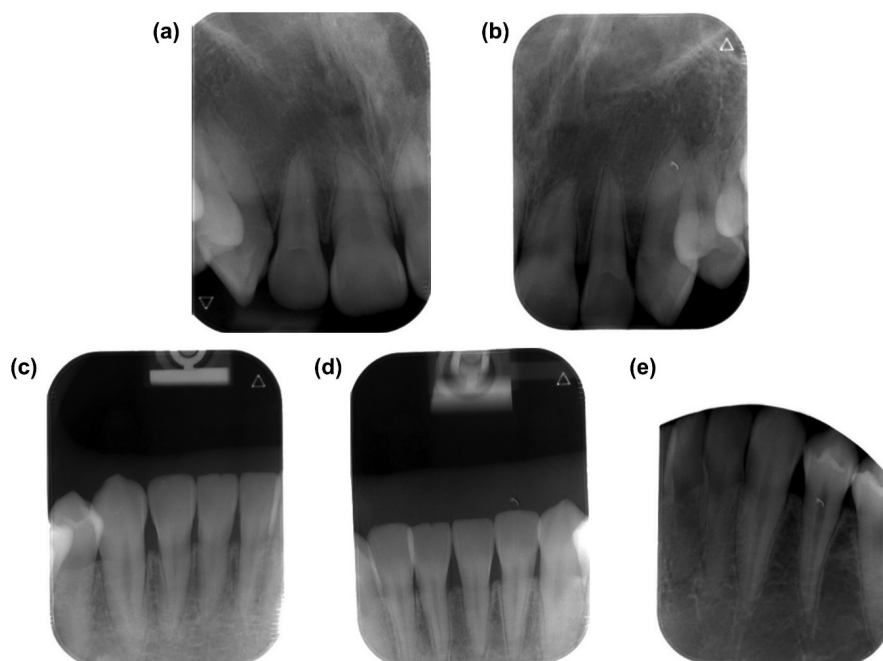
Radiographic images at initial presentation. Intraoral radiographs were taken at (a) right maxillary anterior teeth region, (b) left maxillary anterior teeth region, (c) right mandibular anterior teeth region, (d, e) left mandibular anterior teeth region.
